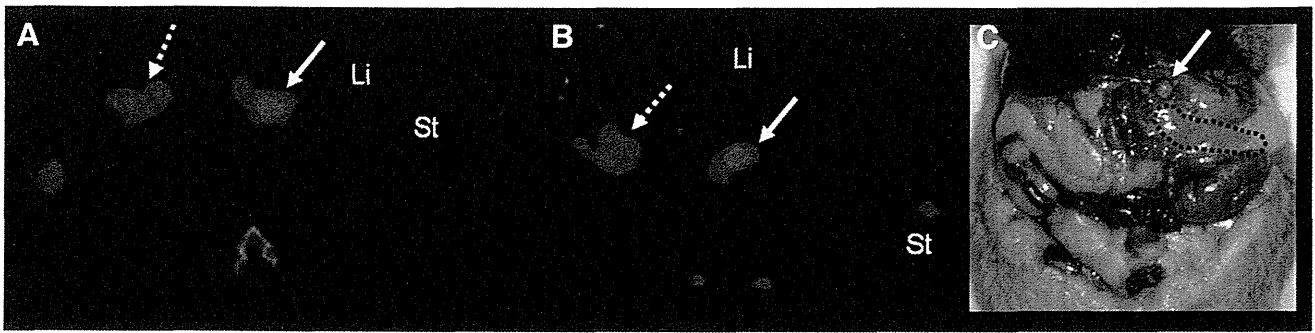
(A and B) SPECT images of pancreatic tumor in hamster 6 (A, axial; B, coronal). SPECT was performed 1 h after injection of ^{111}In -DOTA-c(RGDfK). Intense uptake was found in tumor (solid arrow). Slight uptake of ^{111}In -DOTA-c(RGDfK) was observed in intestine (dotted arrow). (C) Anatomic image of hamster abdomen. Tumor (5 mm) in pancreatic head is indicated by arrow; its position was identical to that of region of high uptake of ^{111}In -DOTA-c(RGDfK). Pancreatic gastric lobe is indicated by dotted line. Li = liver; St = stomach.
